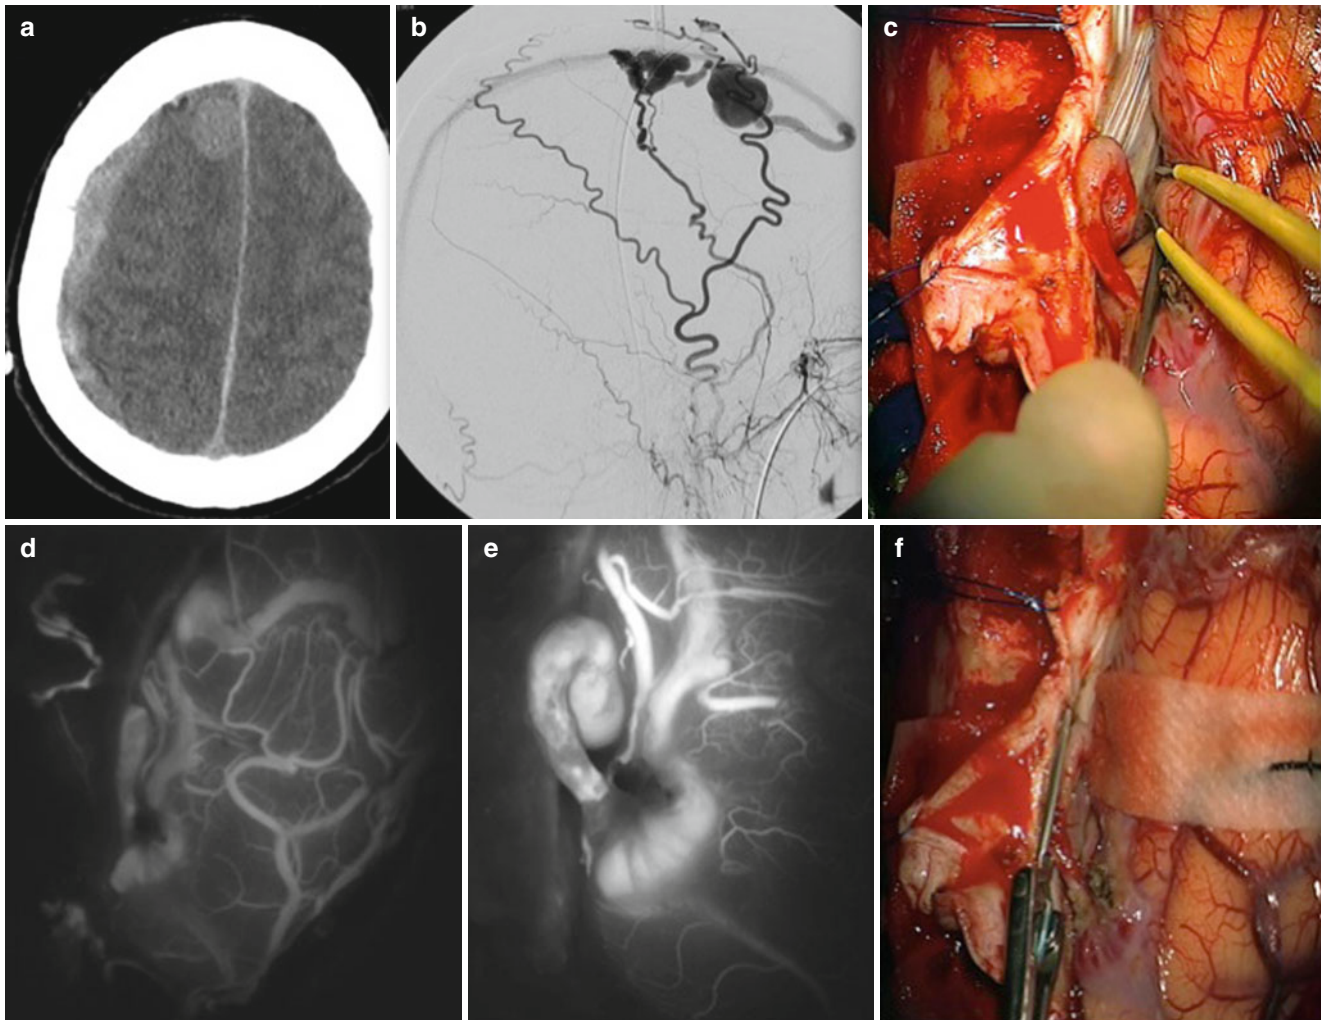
(a) An emergency head CT scan in a patient in a comatose state shows an acute right subdural hematoma. Also evident is a round lesion in the frontal parasagittal area. (b) The DSA confirms the presence of a parasagittal dAVF type IV. (c) Intraoperative picture shows the isolation
